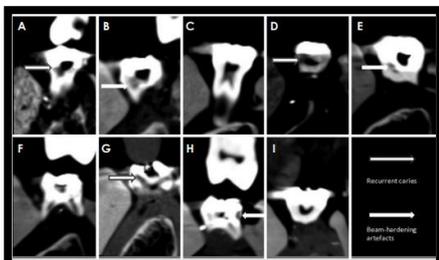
Cross-sectional CBCT images A. amalgam restoration with recurrent caries. B. amalgam restoration with beam hardening artifact. C. amalgam restoration without recurrent caries. D.
